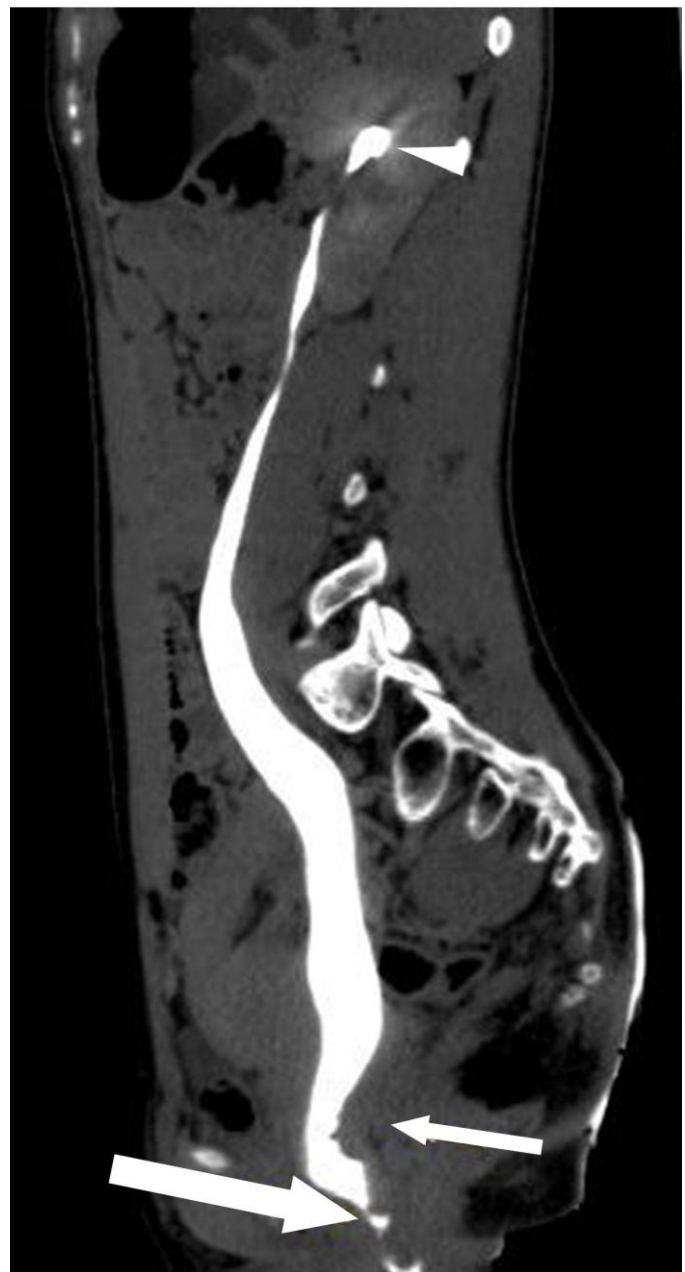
12 year old female with urinary bladder and right renal agenesis. Contrast enhanced CT abdomen in excretory phase with curved multiplanar image shows lower end of left ureter ending ectopically into anterior wall of vagina (thick arrow) with absence of urinary bladder. Thin arrow represents the cervix. Arrowhead represents the minimal dilated upper pole calyx. Protocol: Philips Brilliance 64 slice CT 200 mAs, 120 kV, 1mm slice thickness, 45 ml Omnipaque
